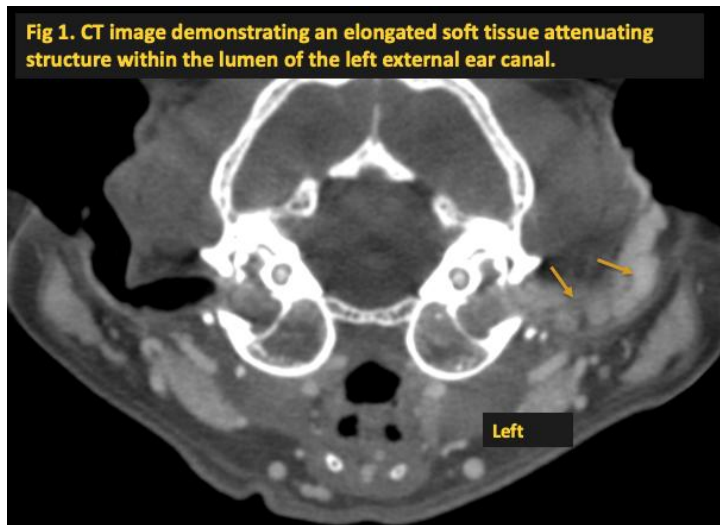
CT image demonstrating an elongated soft tissue attenuating structure within the lumen of the left external ear canal.
